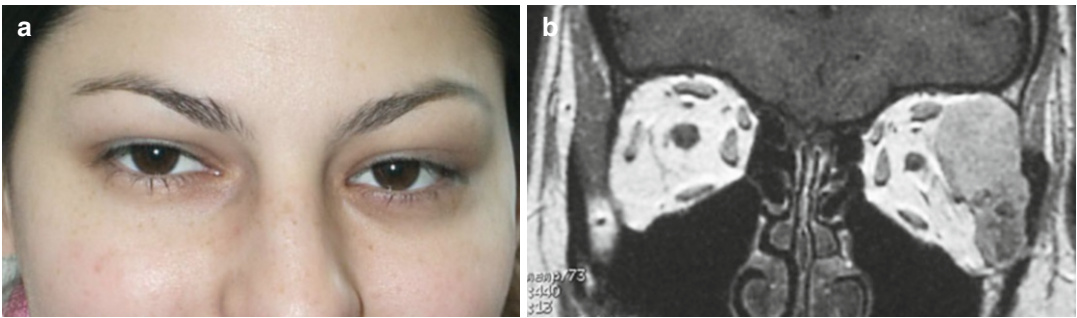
Adenoid cystic carcinoma of the lacrimal gland in the left orbit. (a) Facial photography; (b) coronal MR image. The tumor shows striking heterogeneous enhancement
